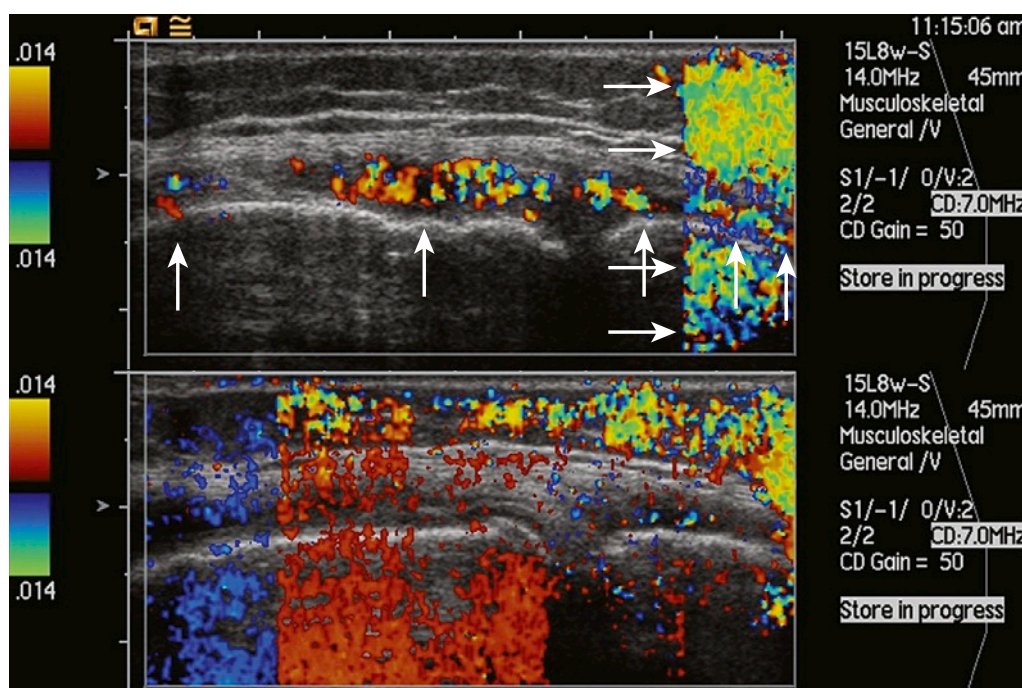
MOTION ARTIFACT. (Top) Movement of the patient or the transducer during Doppler imaging produces motion relative to the transducer and produces Doppler shifts, which appear as random short flashes of large and confluent areas of color. True flow is indicated by *vertical arrows* and motion artifact by *horizontal arrows*. (Bottom) All color is artifact.
